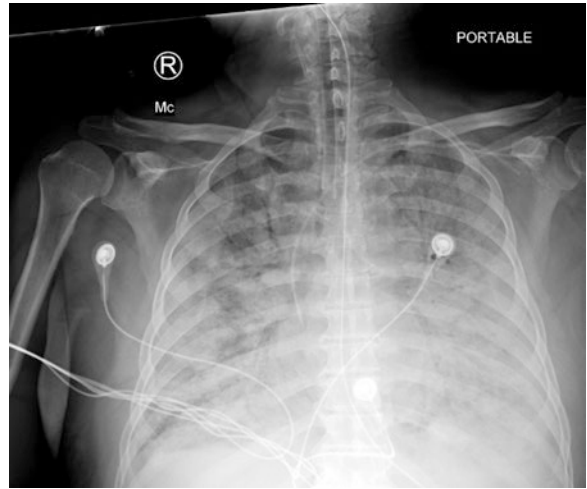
Chest X-ray in a COVID-19 patient with respiratory distress. There are extensive diffuse air space and interstitial opacities in both lungs
